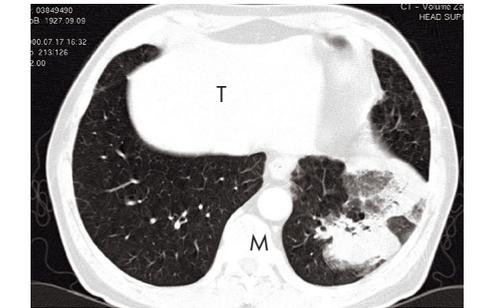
A lung tumour viewed by computed tomography. T= tumour, M= mediastinum
